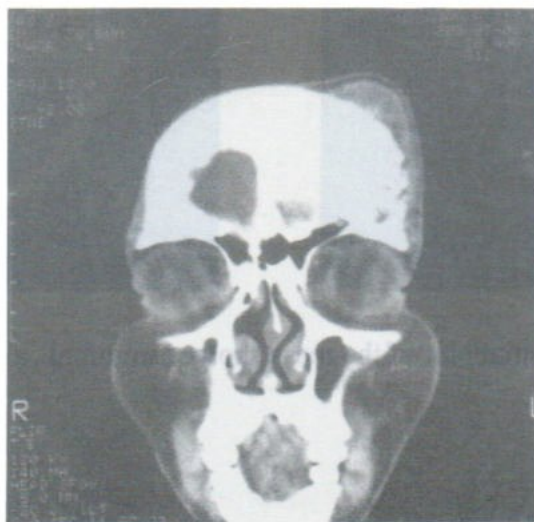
Case 1. CT scan of the lesion showed that the extracranial subgaleal part of the lesion contained no calcification.
